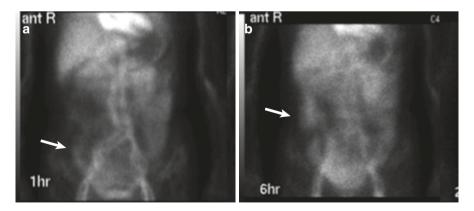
^{99m}Tc-human serum albumin scintigraphy images from case 3. (a) The arrow indicates that the tracer distributed to the small intestine 1 h after the injection. (b) The arrow indicates that the tracer distributed to the ascending colon 6 h after the injection
